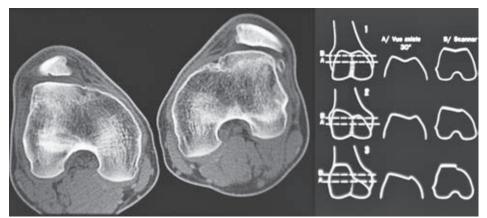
(Original slide) The identification of trochlear bump and the measurement the trochlear depth in X-rays that was not correlated to slice imaging at that time (left).
